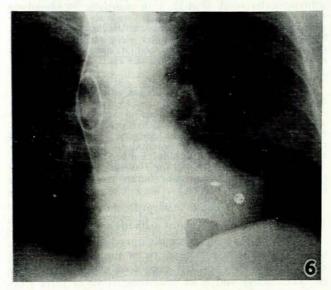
Postero-anterior roentgenogram in case 1, showing a catheter electrode in the right ventricular outflow tract and myocardial electrodes sewn onto the surface of the left ventricle.
